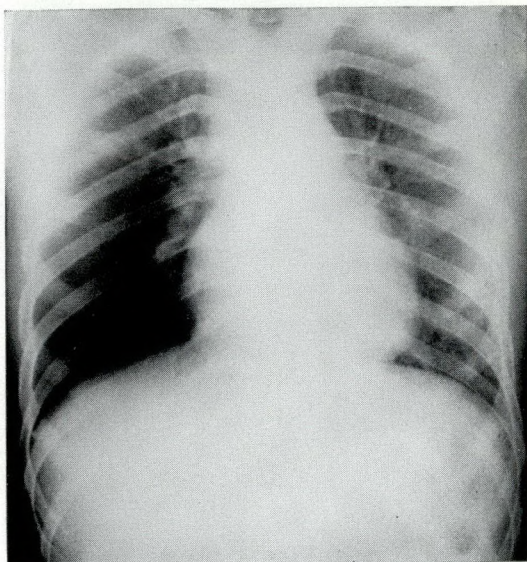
Roentgenogram of the chest taken on admission.
